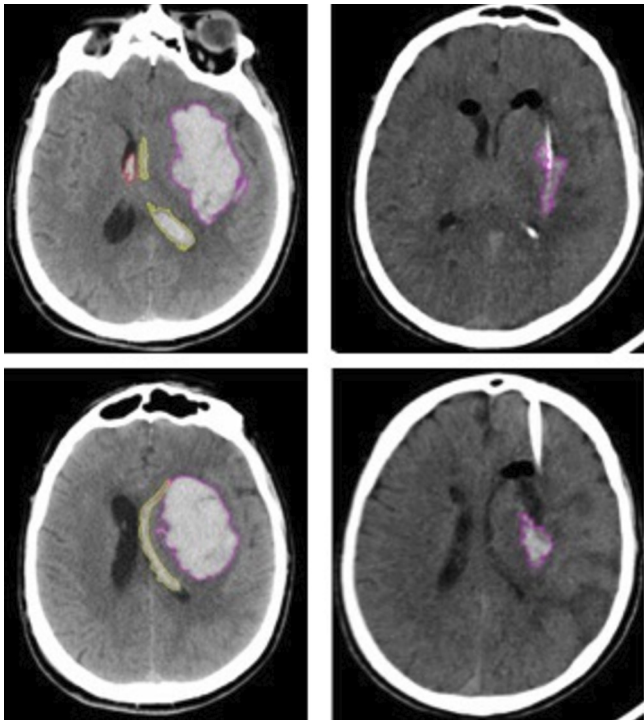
Representative CT imaging of a MISTIE-III subject with concurrent intraparenchymal and intraventricular haemorrhages, taken before (left) and after (right) the MISTIE procedure. MISTIE-III, Minimally Invasive Surgery plus Alteplase for Intracerebral Hemorrhage Evacuation Phase III.
